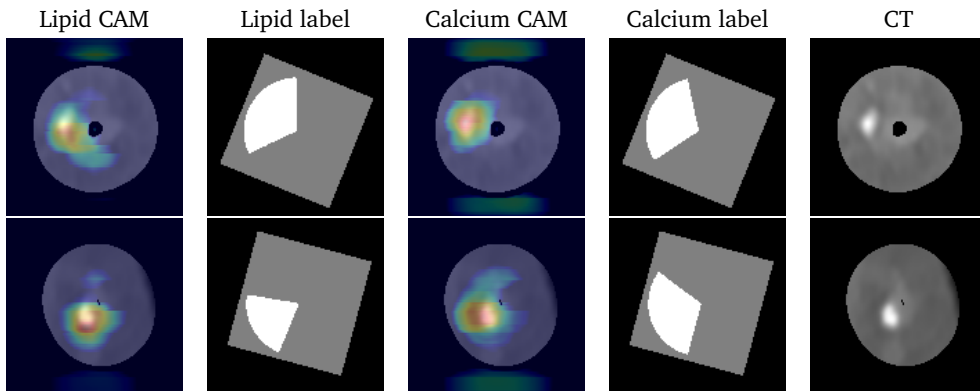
Cross-sectional plaque localization predicted by 2.5D Dense U-Net. From left to right there is the Grad-CAM view of the lipid-rich plaque, pie-shaped label of the lipid-rich plaque, Grad-CAM view of the calcified plaque, and pie-shaped label of calcified plaque as well as the CT image from the LCx (1st row) and from the LAD (2nd row).
